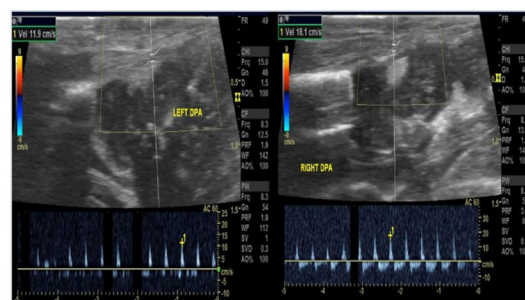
Doppler ultrasound of the dorsalis pedis artery on both sides. The artery shows a patent flow with no obvious intraluminal thrombus or stenosis. The available spectral flow pattern appears unremarkable and the peak systolic velocity is within the normal range.
